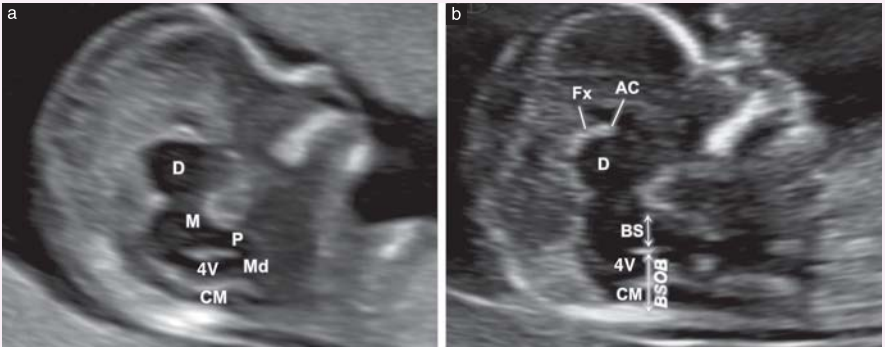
Midsagittal view (frontal approach) of normal fetal brain on two-dimensional ultrasound imaging at 11–13 weeks, showing: (a) detailed anatomy of cranial posterior fossa and (b) measurements of posterior fossa structures and detailed anatomy of visible midline structures. 4V, fourth ventricle; AC, anterior commissure; BS, brainstem; BSOB, brainstem-to-occipital bone distance; CM, cisterna magna; D, diencephalon; Fx, fornix; M, mesencephalon; Md, medulla; P, pons.
